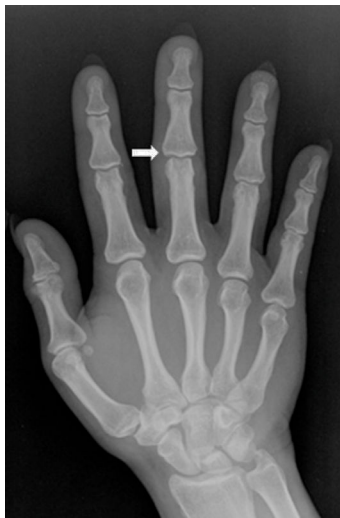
Anteroposterior radiograph at 2 months follow-up demonstrating resolution of the calcified lesion (arrow).
